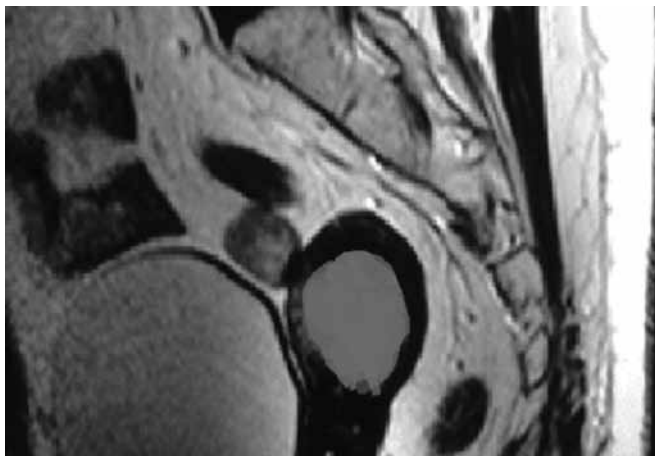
MRI showing the endometrial growth
